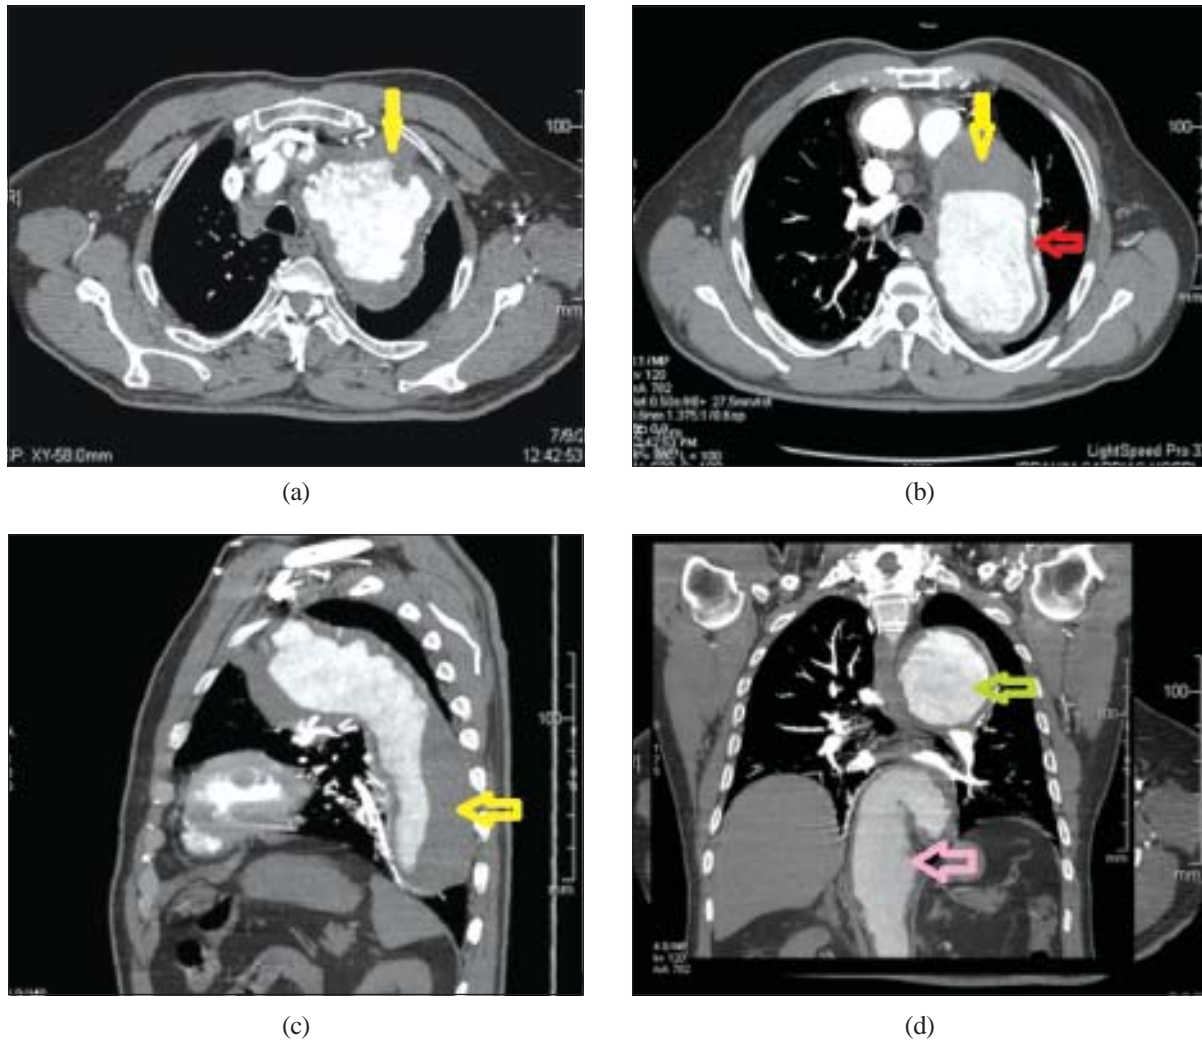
CT scan of chest (a) : Axial plane: Ascending aortic aneurysm showing filling defect (yellow arrow) denoting thrombus. (b): Axial plane: Descending TAA (red arrow) with thrombus (yellow arrow). (c): sagittal plane: descending TAA showing thrombus (yellow arrow). (d): coronal plane showing ascending aortic aneurysm (green arrow) and descending TAA and abdominal aortic aneurysms (pink arrow).
